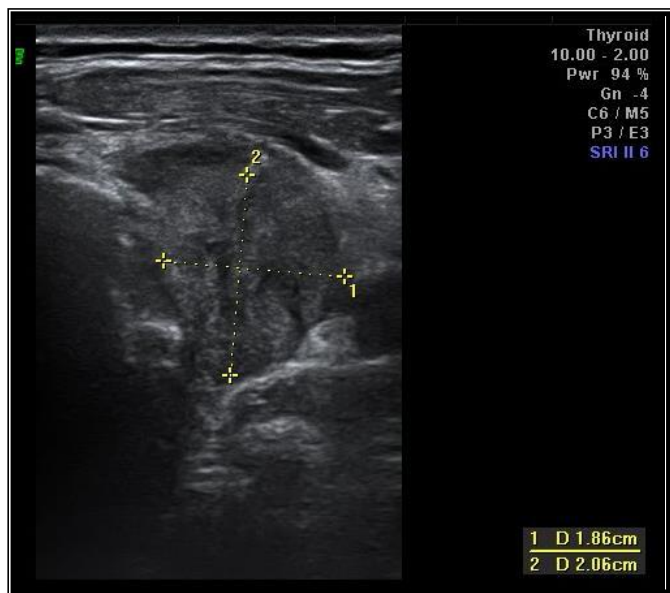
Ultrasound image of the right lobe of the thyroid gland in a transverse plane shows:
